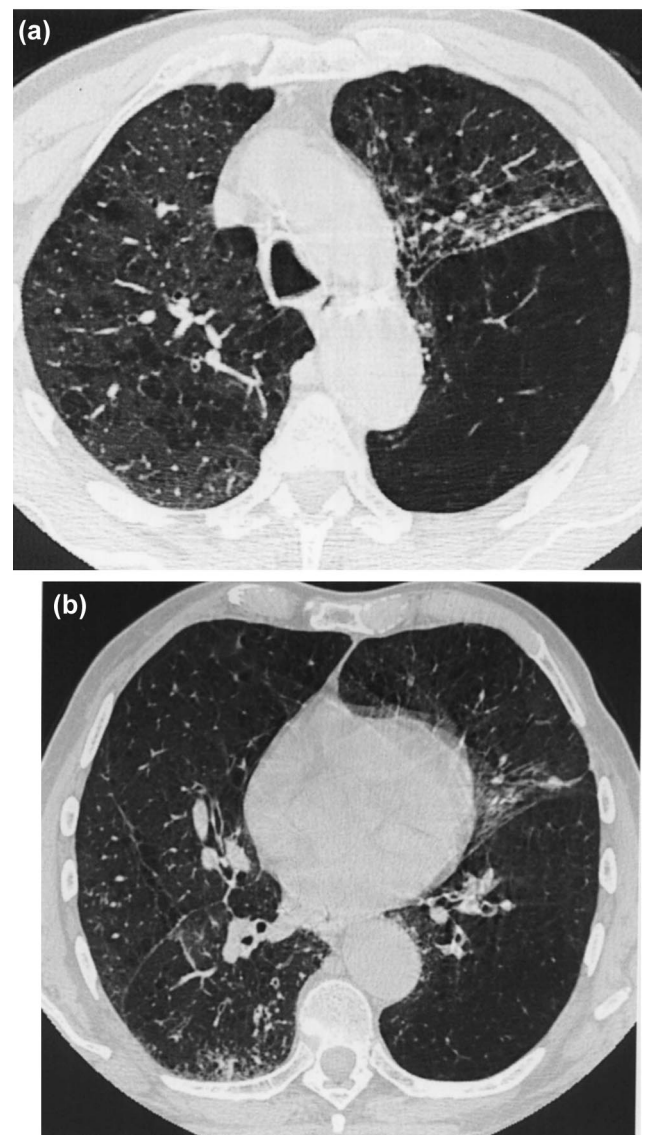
HRCT scans showing asymmetric emphysema. (a) ES: left = 3; right = 1. (b) ES: left = 3; right = 1. ARE = 1.63. Unilateral RP, Δ FEV₁ = 0.43 l.
